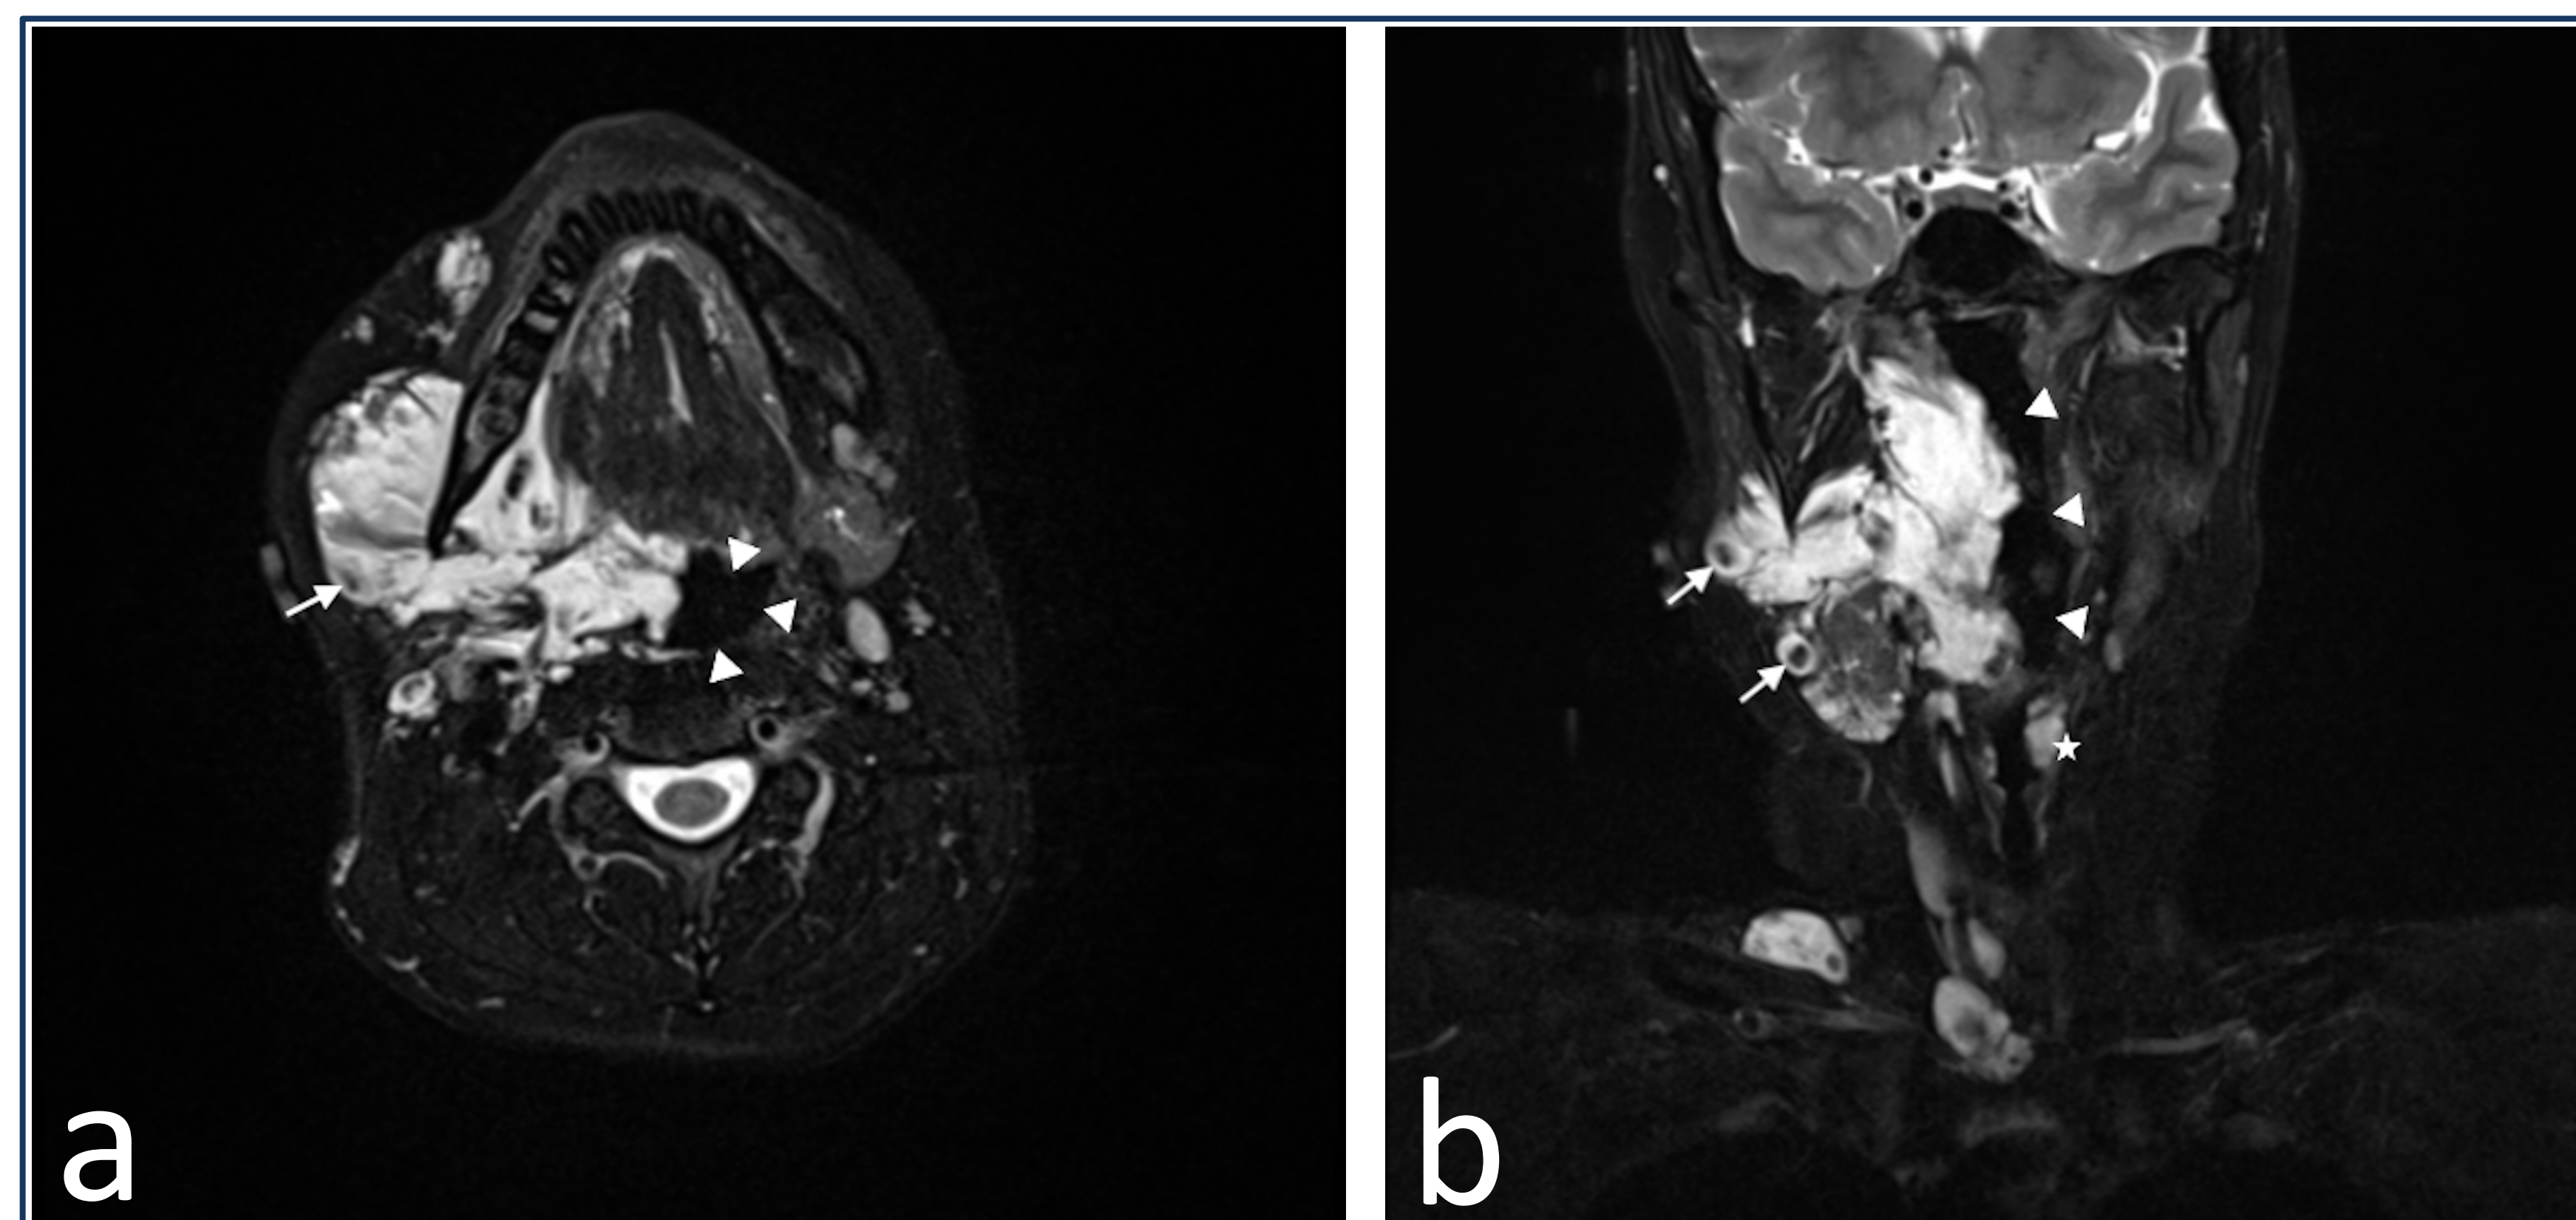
T2-weighted MR (1.5 Tesla, Aera, Siemens, Germany) axial (a) and coronal (b) images with fat-saturation (echo time = 90ms, repetition time = 5700ms, flip angle = 160°) showing a trans-spatial hyperintense venous malformation within the right face and neck, primarily centred within the right masticator space with extension into the right buccal space, right parapharyngeal space, right sublingual and submandibular spaces, and right parotid space. It also involves the right aspect of the tongue with mass effect on the right oropharynx (arrowheads), left aspect of the larynx (star), right sternocleidomastoid muscle, and right supraclavicular region. T2 hypointense foci are noted within the right masticator component corresponding to phleboliths (arrows).
